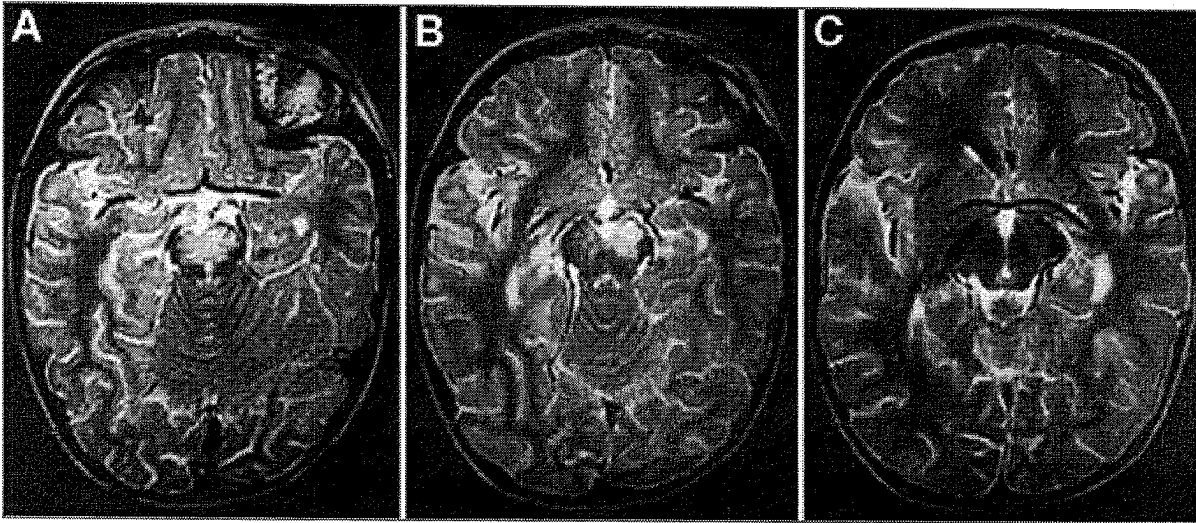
T2-weighted MRI scans showing signal change in the ventral midbrain.
